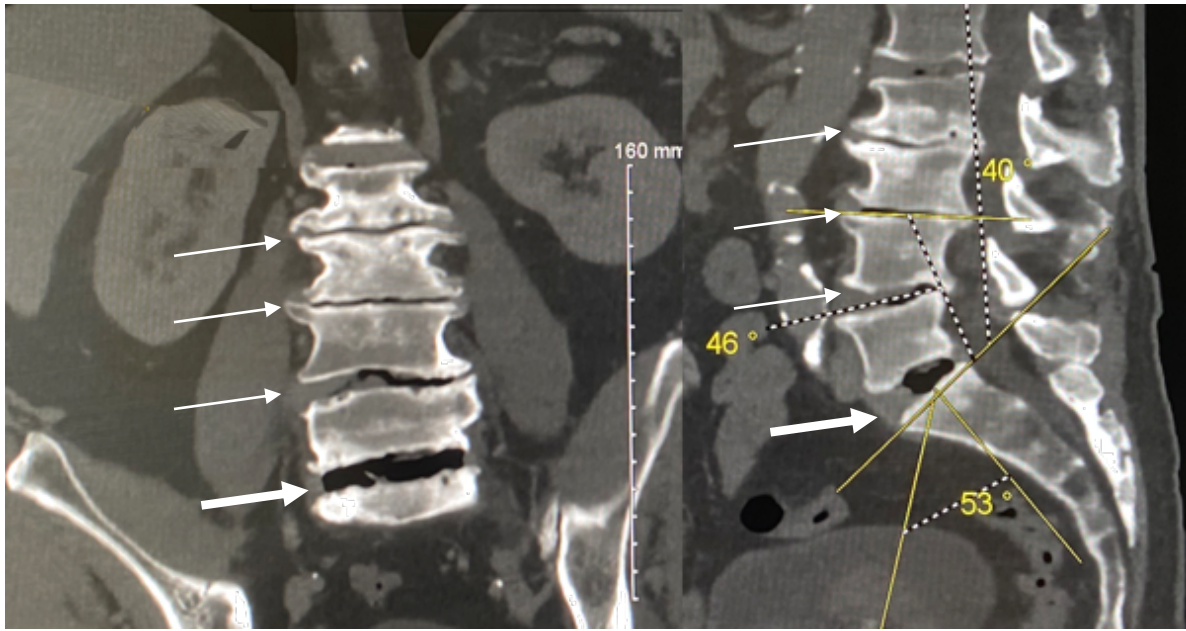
CT scan with coronal and sagittal reconstructions. Large IDVP noted at L5S1 (big arrow) with lesser IDVP noted at additional levels (small arrows). Additional evidence of disc degeneration was evident including disc osteophytes, end plate sclerosis and collapse.
